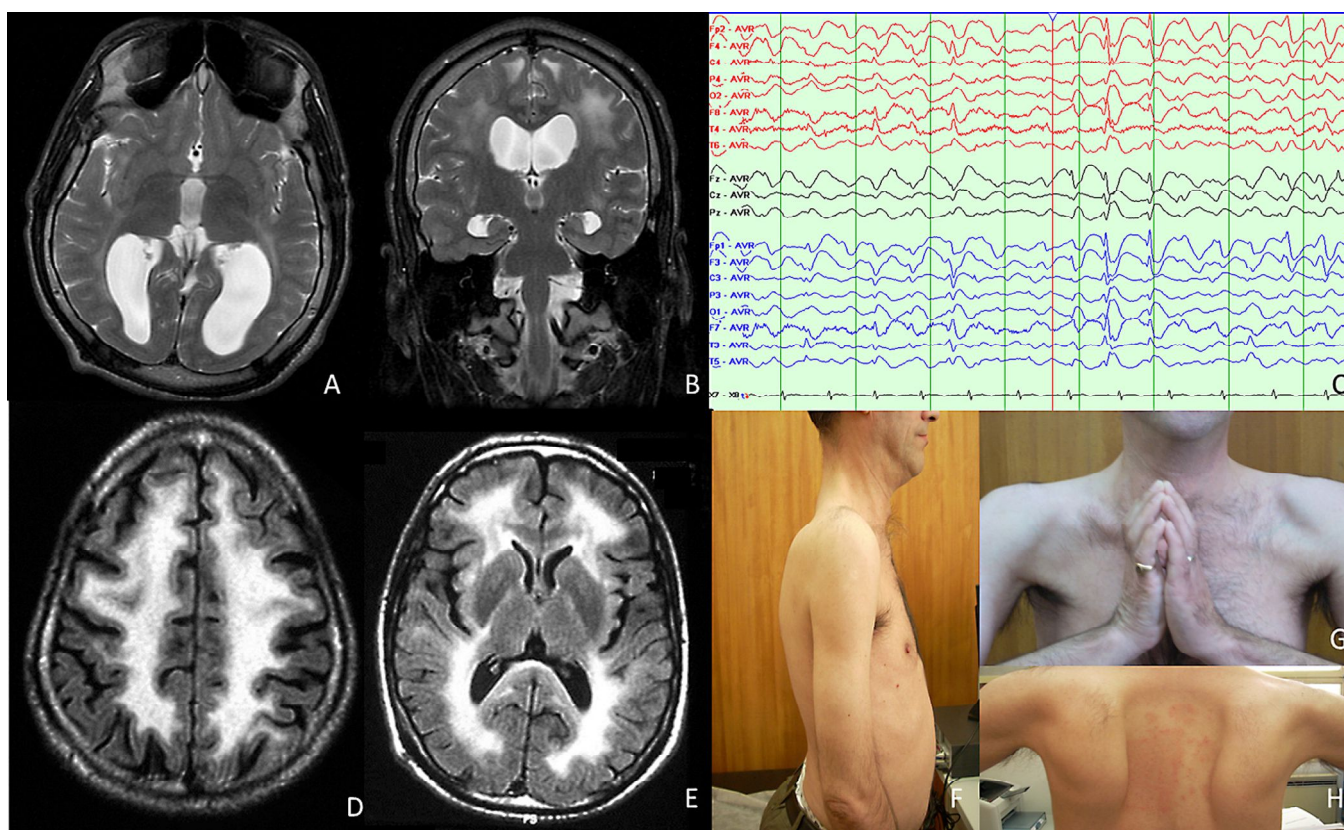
T2-weighted axial (A) and coronal (B) brain MRI of patient 1 at age 15; note the occipital agyria and white matter hyperintensity; (C) EEG of patient 1: diffuse slowing of background activity; bilateral paroxysms, stronger in the anterior regions. (D and E) Axial FLAIR T2-weighted brain MRI of patient 2 with extensive white matter hyperintensities; (F) lumbar hyperlordosis in patient 2; (G) tendinous retractions in patient 2; (H) scapular winging in patient 2.
